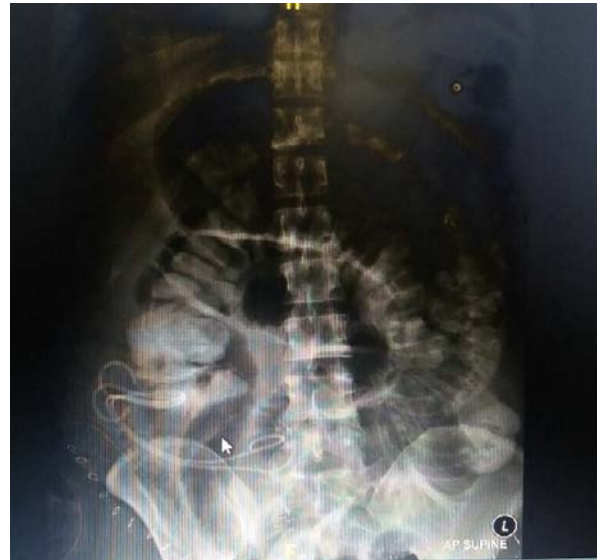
Abdominal X-ray in adult Hirschsprung's disease
